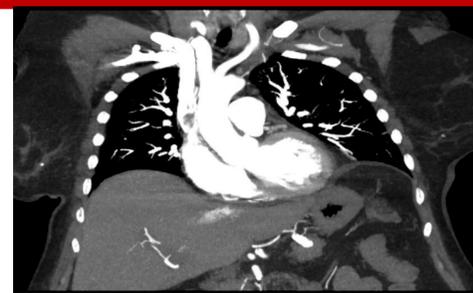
CTA chest w/ no evidence of aortic dissection or PE
